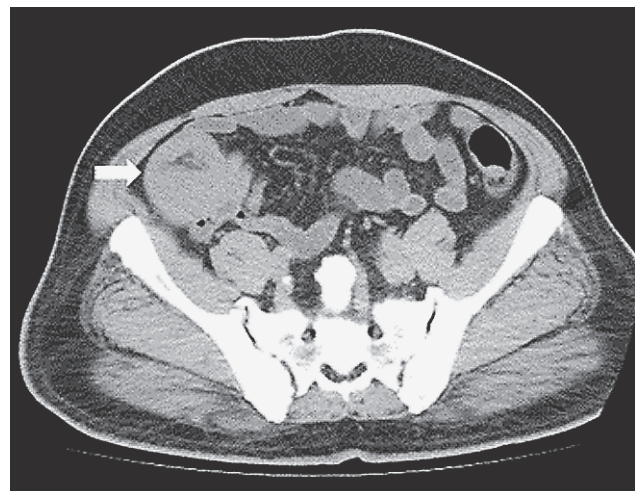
Plain abdominal computed tomography (CT) scans revealed an intussusception of the ileum (arrow).
